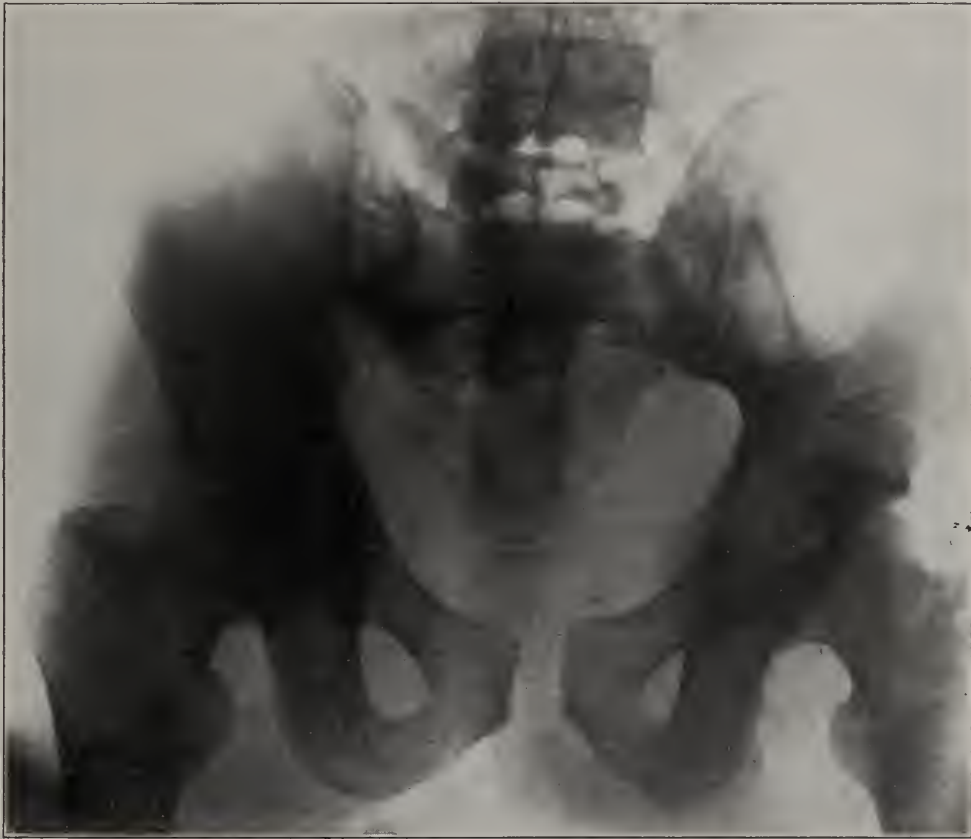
X-ray picture taken before treatment was begun.
